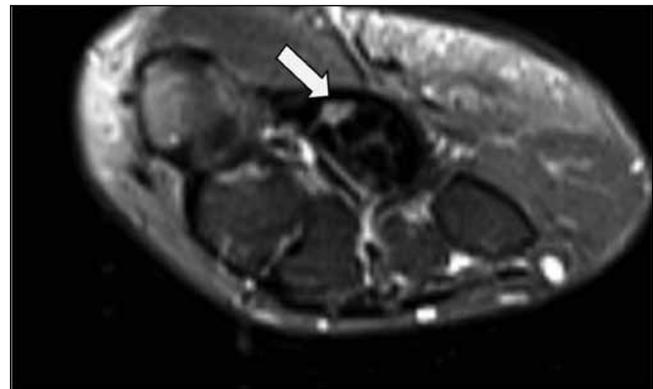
White arrow in T2-weighted MRI appearance of mid-level CTS.
